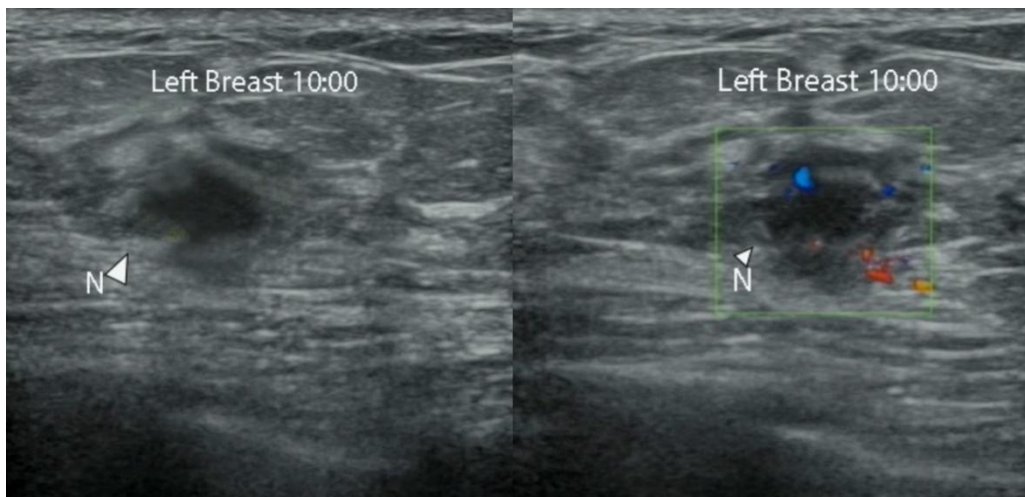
Ultrasonography: Hypoechoic nodule in the left breast at 10 o'clock, unclear boundary, the halo sign visible on the periphery, and punctate blood flow signals seen on CDFI. N: nodule
